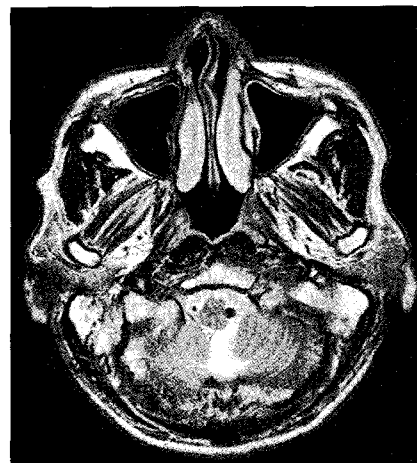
Preoperative T2-weighted magnetic resonance image showing compression of the medulla by medial deviation of the vertebral artery.
